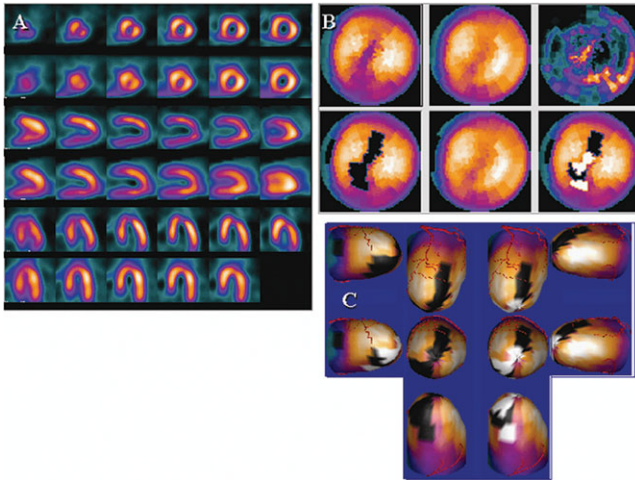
SPECT myocardial perfusion study. The radiotracers used in this study reflect the blood flow in the heart wall. Separate SPECT studies are acquired when the patient is in a normal resting state, and when the patient is subjected to a physical activity or a drug that requires more myocardial blood flow. Comparisons of these two studies indicate whether the patient is disease-free, has limited blood flow capacity (ischemia), or has permanent damage to the heart wall (infarct). (a) Tomographic stress and rest images of myocardial perfusion. The studies are often mapped to either circular (bulls-eye) or cylindrical (bullet) displays for easier viewing. (b) “Bulls-eye” display of myocardial perfusion. (c) “Bullet” display of the myocardial perfusion images.
